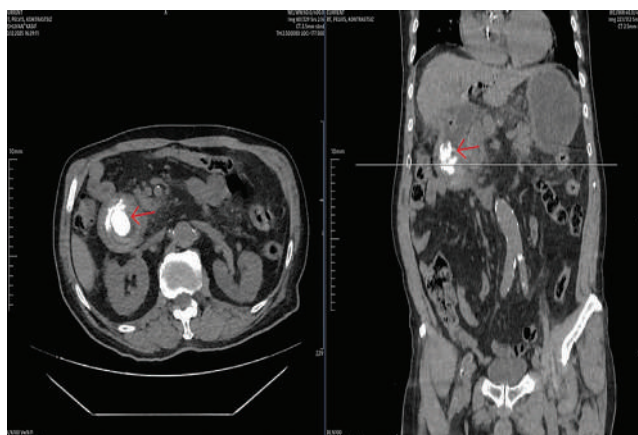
Axial and coronal CT images of the case.
